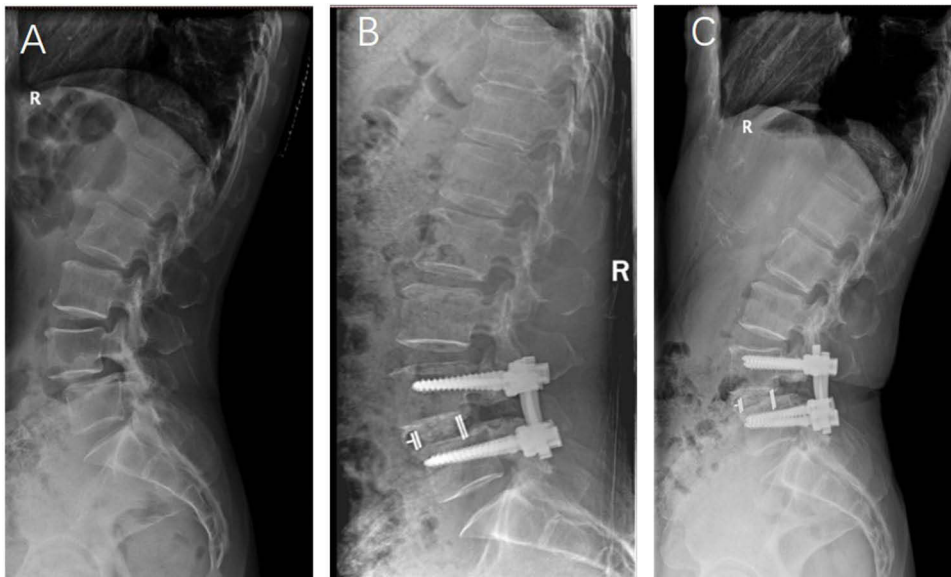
A 62-year-old female patient. (A) Preoperative lateral X-ray of the lumbar spine indicating degenerative spondylolisthesis at the L4 vertebra; (B) postoperative X-ray of the lumbar spine 1 week after TLIF surgery showing recovery of the intervertebral space height at the surgical segment, with good positioning of the screws and rods, and no anteroposterior sliding or subsidence of the cage; (C) X-ray of the lumbar spine at the last follow-up indicating significant loss of intervertebral height at the surgical segment, with notable cage subsidence.
